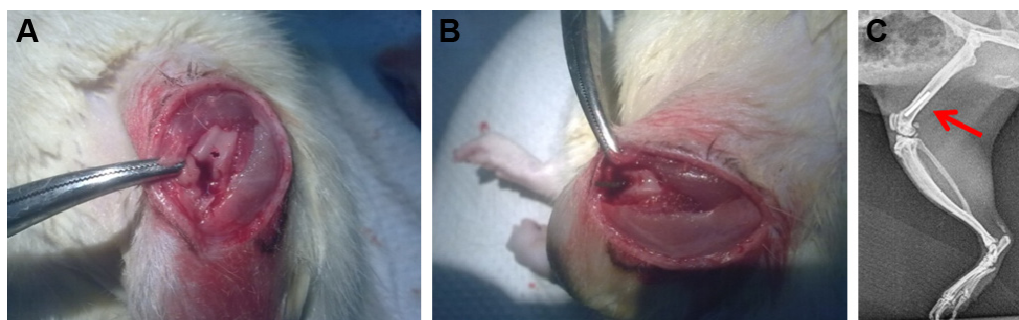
Consecutive stages of implantation: (A) opening of femur medullary canal and (B) implant insertion. (C) Red arrow shows location of the implant on lateral X-ray picture.
